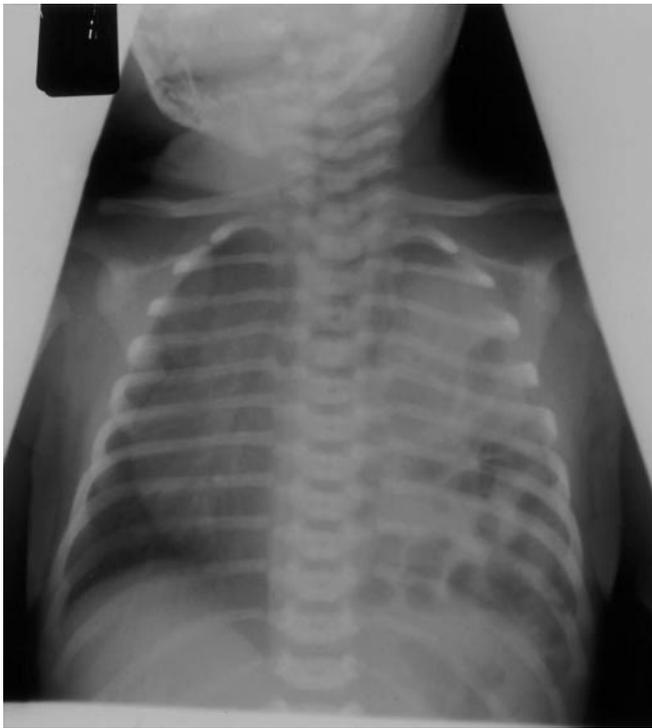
Typical chest x-ray findings of a left-sided congenital diaphragmatic hernia, showing mediastinal shift and multiple loops of bowel in the left thoracic cavity.
